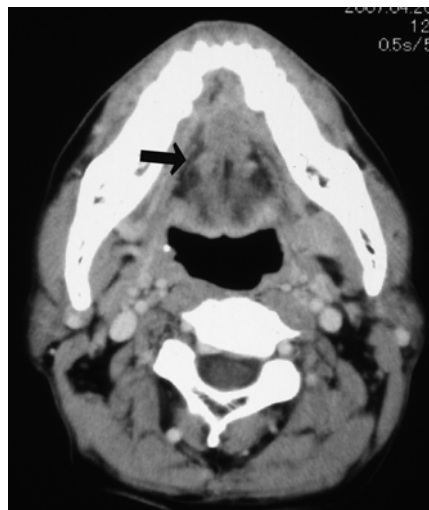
MRI image of Case 2 showing the lateral lingual lymph node.
